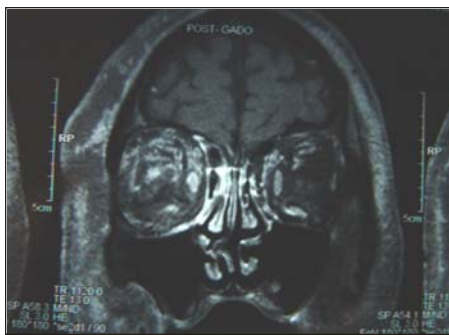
Gadolinium enhanced MRI scan of the patient shown in Figure 2 demonstrating heterogenous areas of contrast enhancement, within the thickened soft tissues of the scalp and eyelids on the right side of the face. There is evidence of right sided ethmoid sinusitis, enhancement of the retrobulbar tissues and the optic nerve on the right side, with distortion of the ocular walls. The above radiological findings co-related with the diagnosis of right sided facial and orbital cellulitis, endophthalmitis and optic neuritis. A skin biopsy, as mentioned above confirmed aspergillosis nigra.
